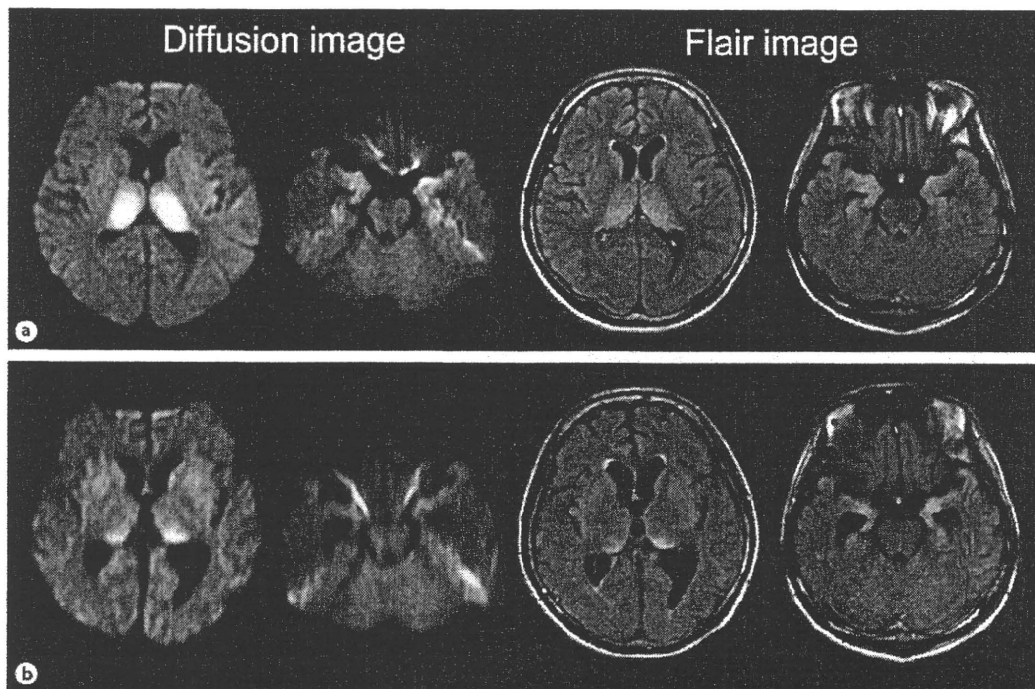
Brain MRI findings. a Images on the 42nd hospital day showed high-intensity lesions in the bilateral thalamus and bilateral medial temporal lobes. b Images on the 64th hospital day revealed improved abnormal high-intensity lesions in the bilateral thalamus but progressive atrophy of the bilateral medial temporal lobes.
